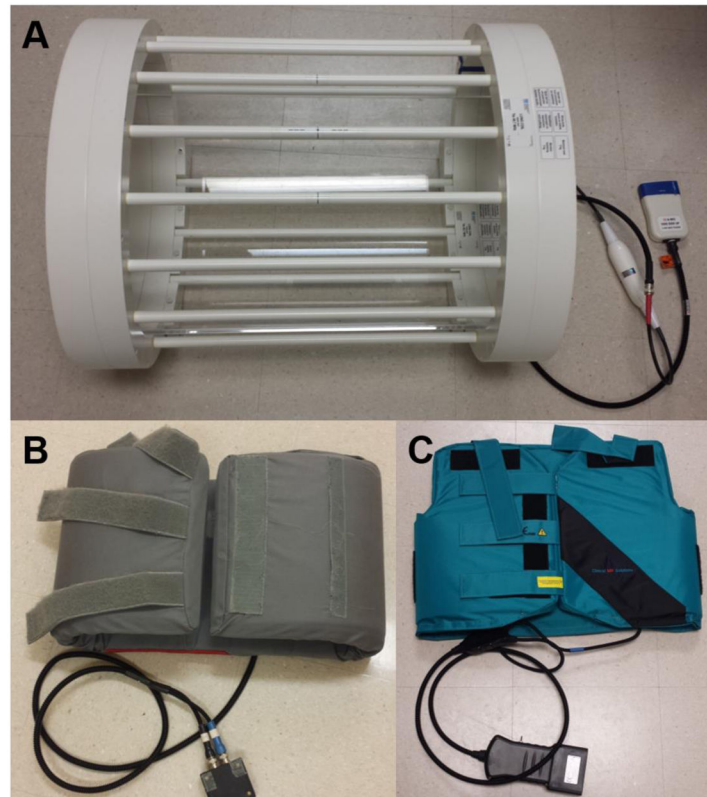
Representative images of a HP ^3He receive birdcage coil (A), HP ^3He receive phased-array coil (B), and HP ^{129}Xe receive phased array coil (C), all used for pulmonary MR imaging. RF excitation is provided via the broadband capabilities of the MR system.
